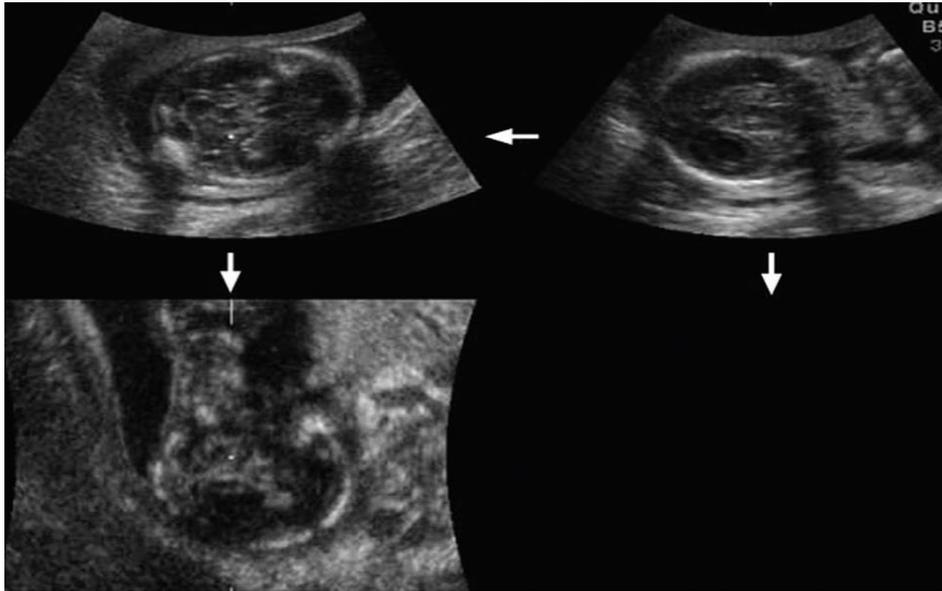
Multiplanar display of 3D ultrasound volume shows fetal head in three orientations perpendicular to each other.
